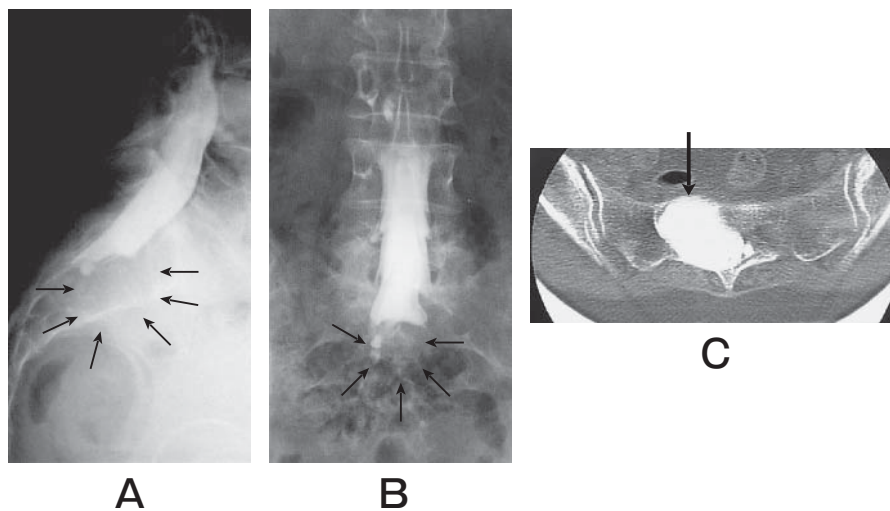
Myelography and CT of the sacral perineural cyst. A, The figure shows a lateral myelogram. The cyst was not immediately filled with dye (small arrow); B, The figure shows an anteroposterior Myelogram; C, CT-myelography shows that the cyst was filled with dye at 6 h post-myelography, which means that there was communication between the cyst and the arachnoid space (big arrow).
